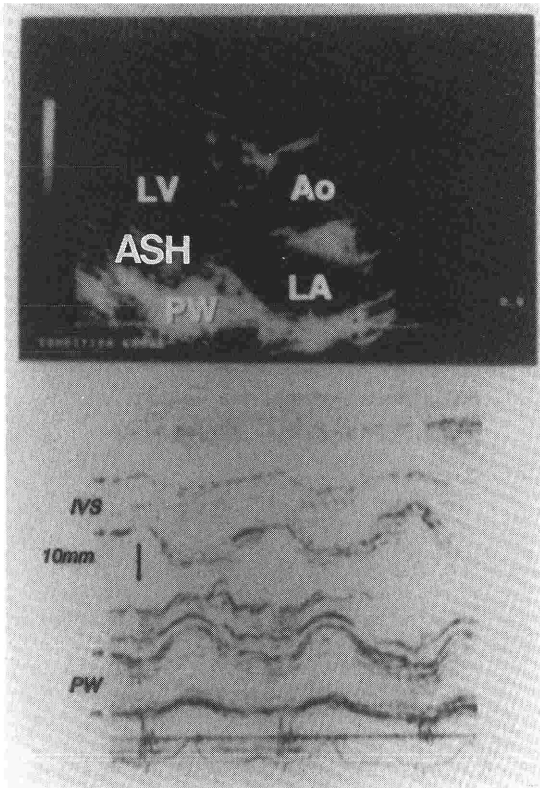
Transthoracic echocardiography displays the following features:
